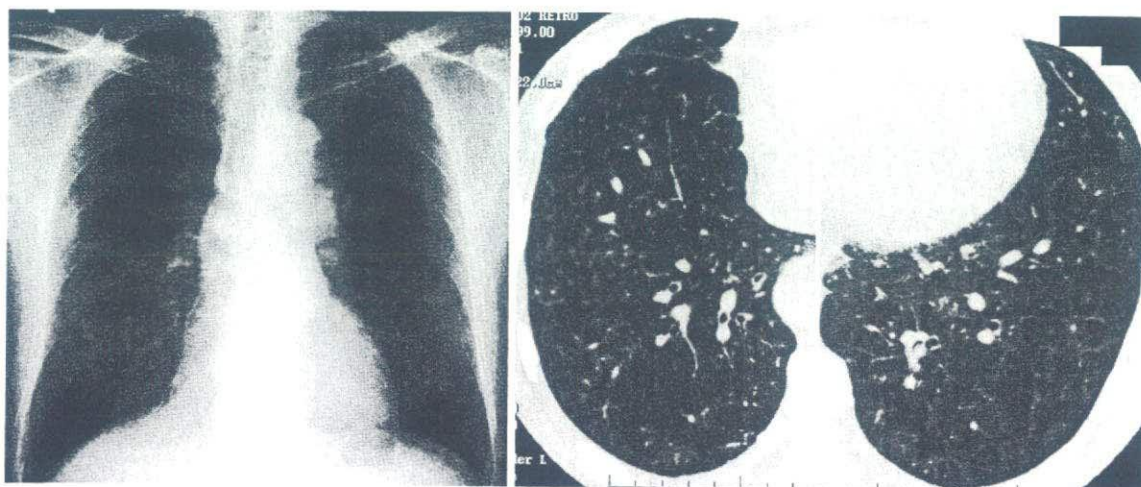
Chest radiograph and CT scan on admission of Case 1 showing diffuse small nodular lesions with diffuse ground-glass opacity in both lung fields.
